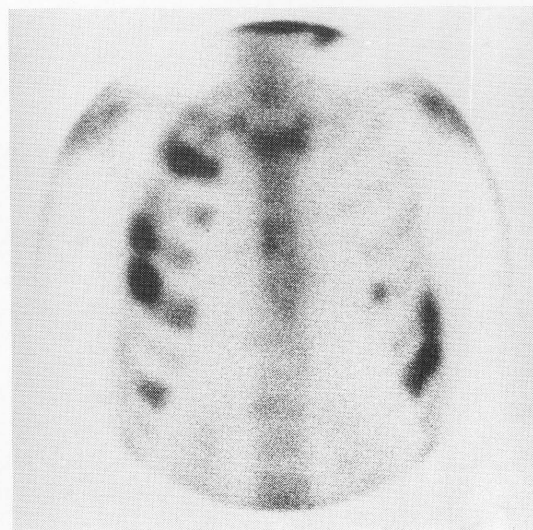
Spot images of the head (A) and the chest (B) in bone scintigraphy performed at four hours after intravenous injection of 20 mCi of Tc-99m MDP revealed increased uptake of Tc-99m MDP in the area corresponding to the lesion shown in the radiograph.
